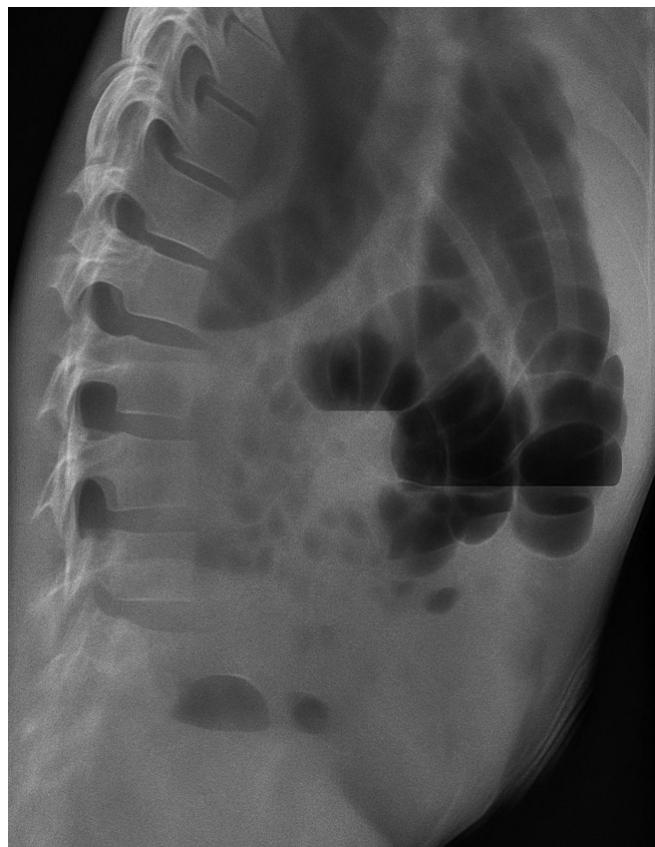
An erect abdominal X-ray showing multiple air-fluid levels on the right lower abdomen, but no evidence of free subdiaphragmatic air.
